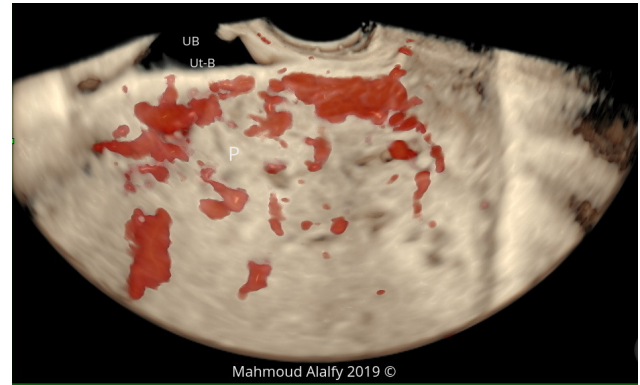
3D Power Doppler. Demonstrating the placenta and the placental vessels invading the myometrial wall (large longitudinal arrow) and shows the placental hyper vascularity (transverse arrow). UB, urinary bladder; Ut-B, uterine bladder interface; P, Placenta.
